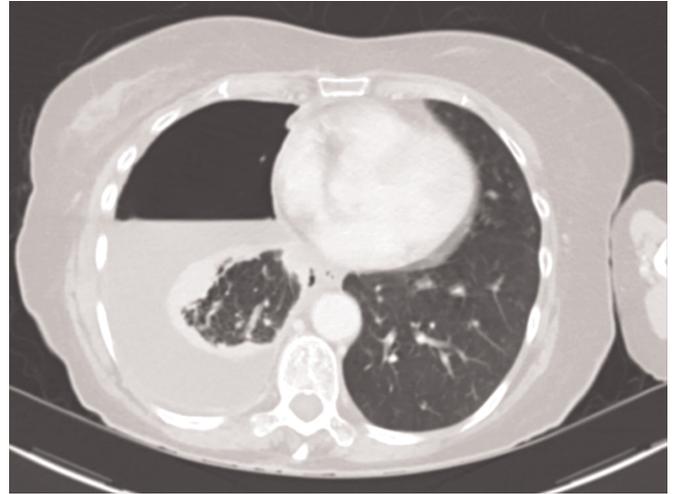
Computed tomography image to accompany self-evaluation question 1.
